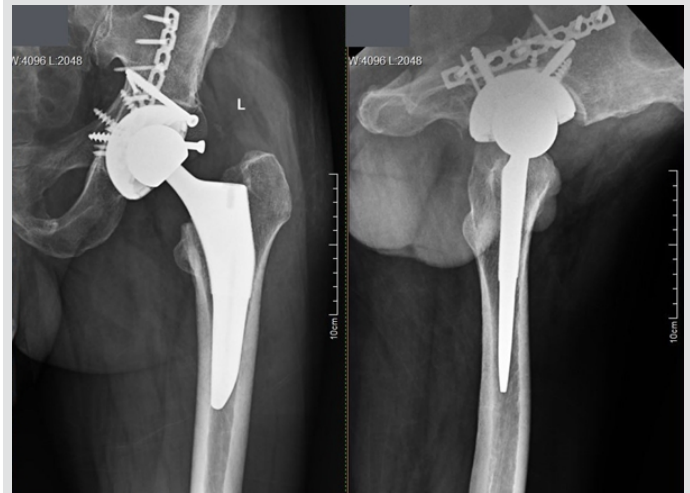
Anteroposterior and lateral radiograph of left hip showing healed fracture with stable total hip arthroplasty in situ.
